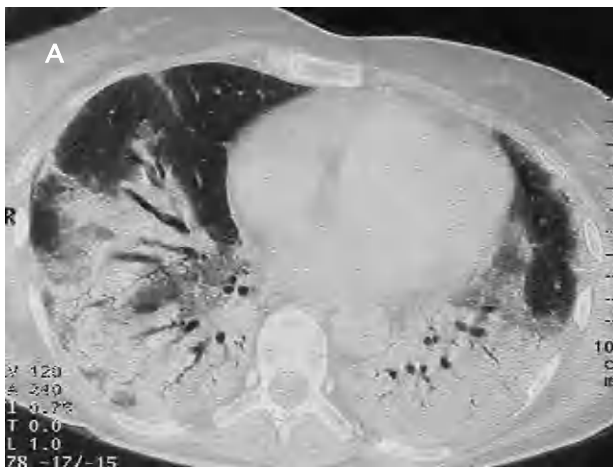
Patient 51 years of age with polymyalgia rheumatica (A): axial scan of 1 mm collimation showing extended parenchymal consolidation in both lower lobes, with dilated bronchioles in the interior. Patient with rheumatoid arthritis who presented dyspnea and dry cough (B): high resolution computed tomography of the lung bases revealed diffuse ground glass opacities, dilated bronchioles, and patchy subpleural septal thickening.
